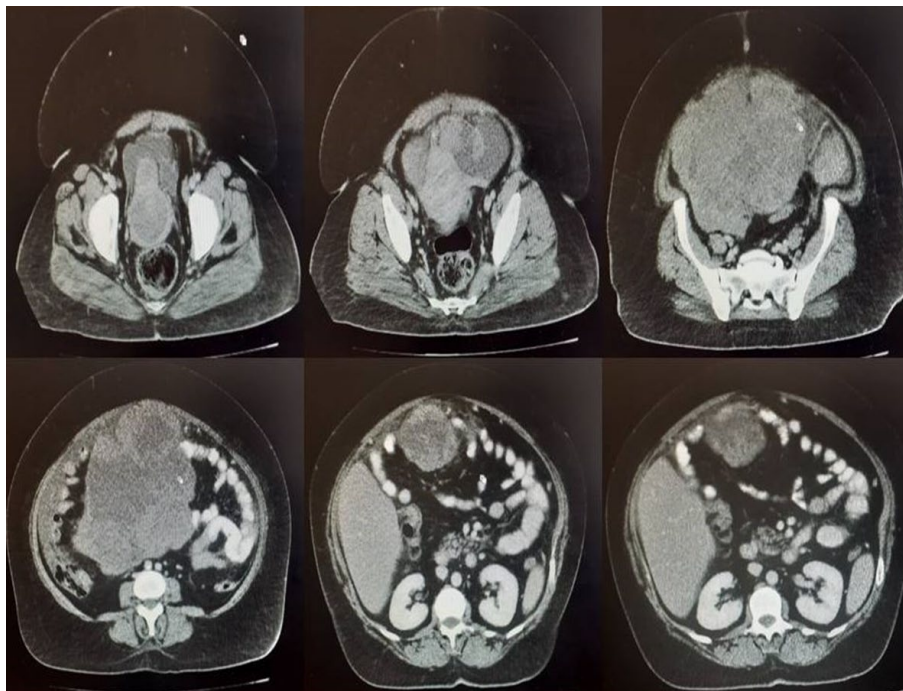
Compilation of CT images demonstrating a complex pelvic mass extending to the upper abdomen.
